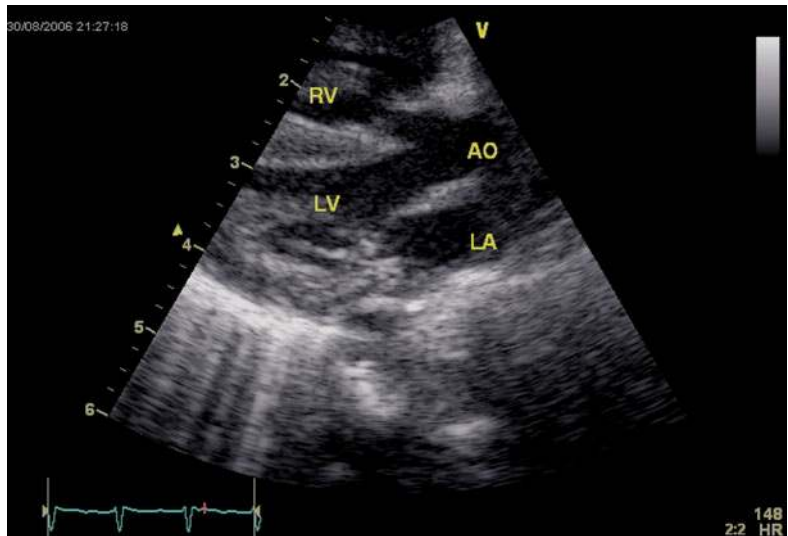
Parasternal long axis view demonstrating moderate malalignment VSD with aortic override in a patient with Tetralogy of Fallot
